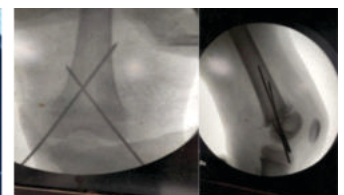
Radiograph after post OT
